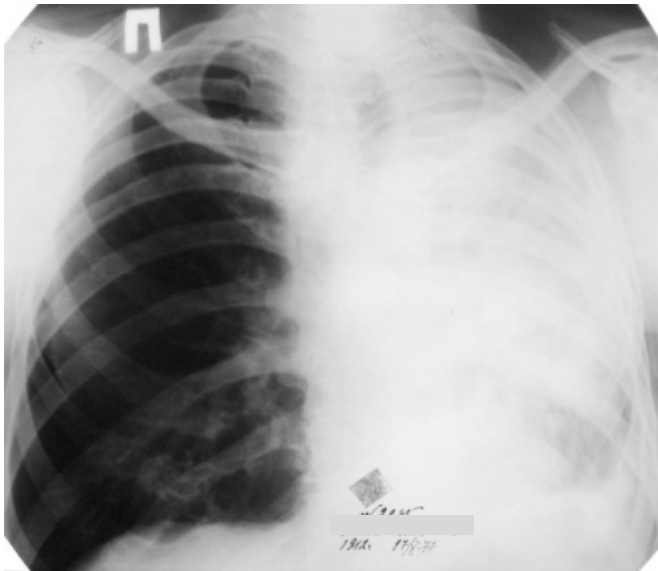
Total shadow in the left pulmonary field. Posterior-anterior chest radiograph of a patient with obstructive atelectasis of the left lung due to central bronchogenic carcinoma
